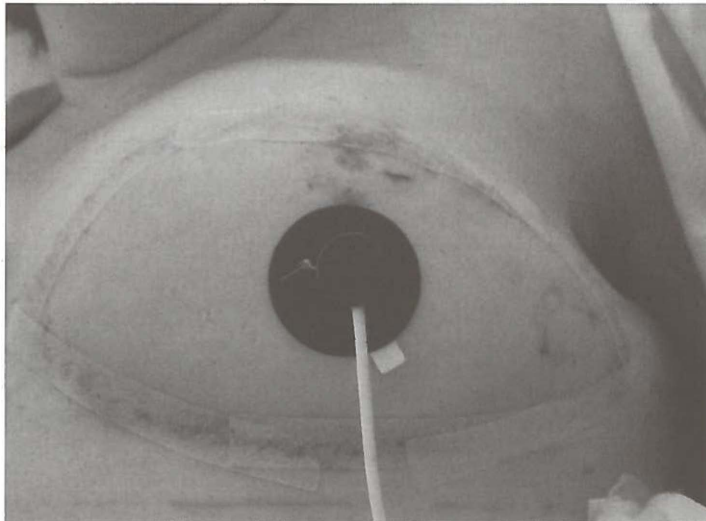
Laser Doppler flowmetry monitoring of a deep inferior epigastric perforator flap reconstruction.
